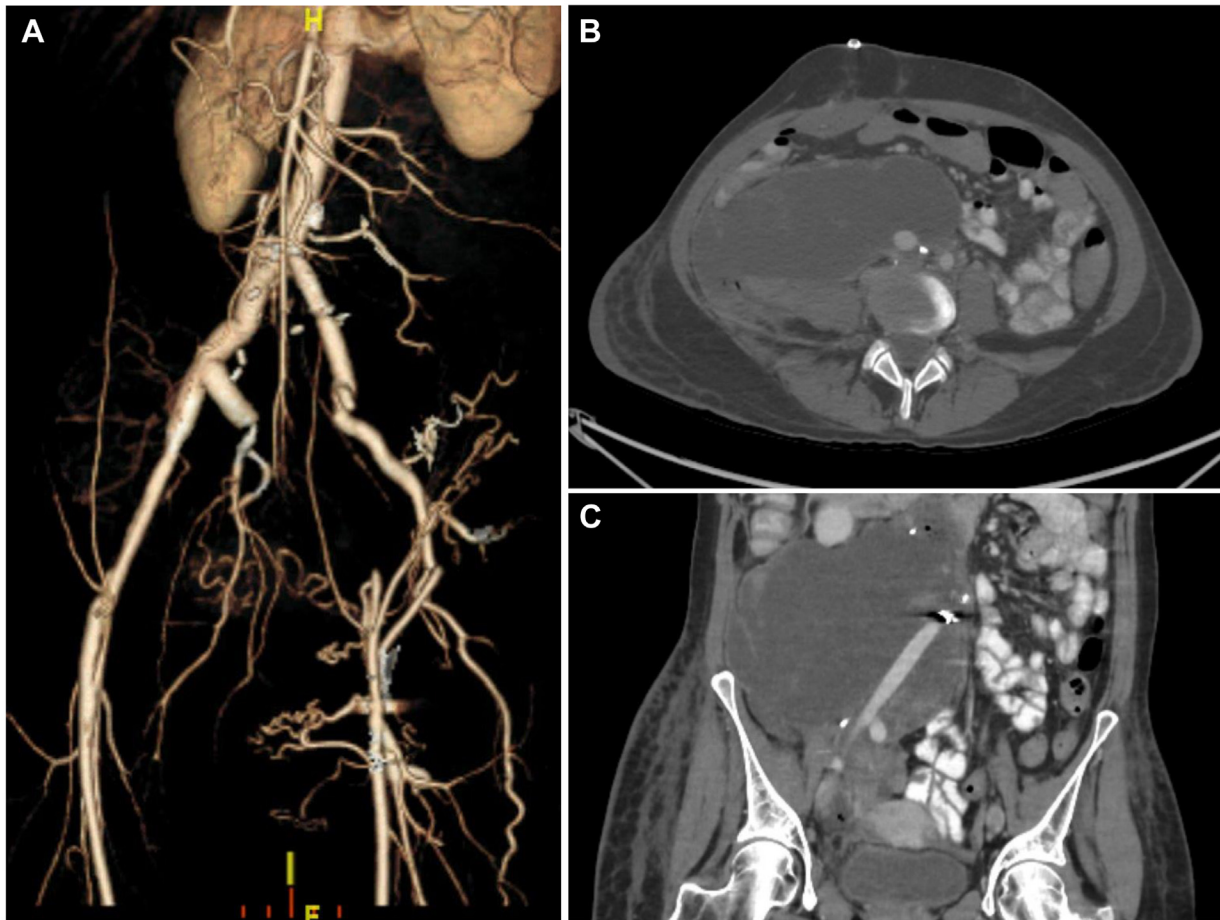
Computed tomography angiography (CTA) of the patient after elective repair of right iliac artery. A, Three-dimensional reconstruction showing interposition right common iliac artery (CIA) to external iliac artery bypass using an 8-mm Dacron graft and end-to-side reconstruction of the right internal iliac artery (IIA) using an 8-mm Dacron graft. Axial (B) and coronal (C) images showing large postoperative retroperitoneal hematoma.
